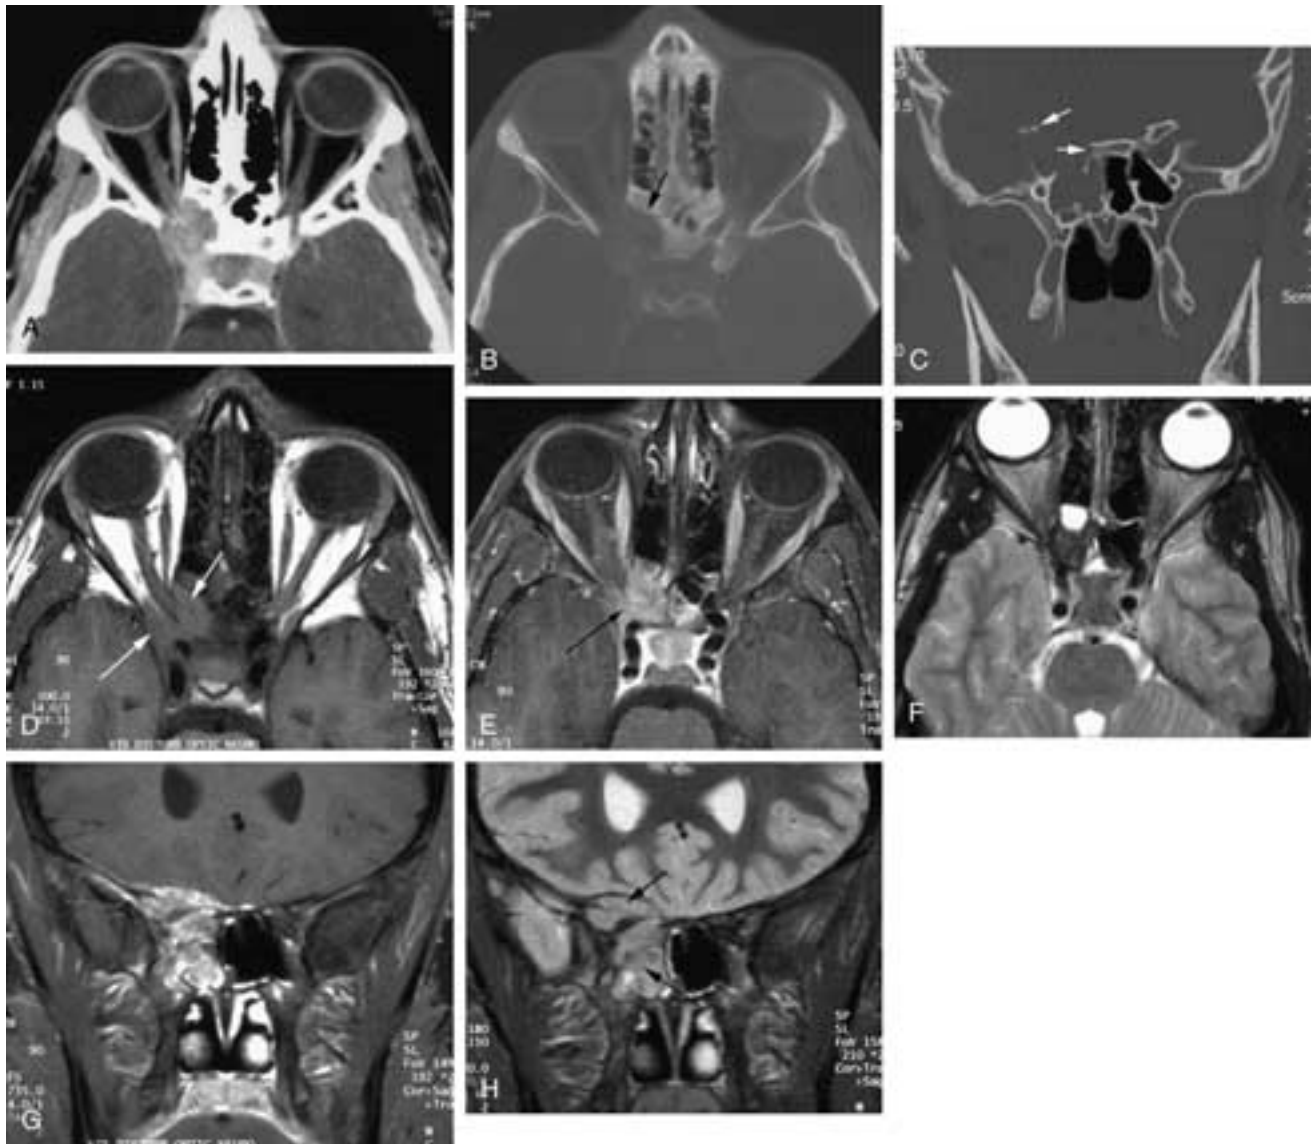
Langerhans histiocytosis (eosinophilic granuloma). A, Axial postcontrast CT algorithm shows a lesion in the orbital apex and lateral sphenoid with slight enhancement. B, Axial CT bone algorithm shows the lesion with a sharp margin (*arrow*). Note the demineralization around the optic nerve canal. C, Coronal bone algorithm shows a sharp nonsclerotic margin (*arrows*). D, T1-weighted MR image shows intermediate signal intensity of the lesion (*arrows*). E, Postgadolinium image shows moderate enhancement (*arrow*). F, Axial T2-weighted image shows the lesion to be relatively dark. G, Coronal postcontrast image shows the lesion bulging the dura superiorly and involving the apex as well as the lateral sphenoid. H, Coronal STIR (Short Tau Inversion Recovery) lesion (*arrows*).
